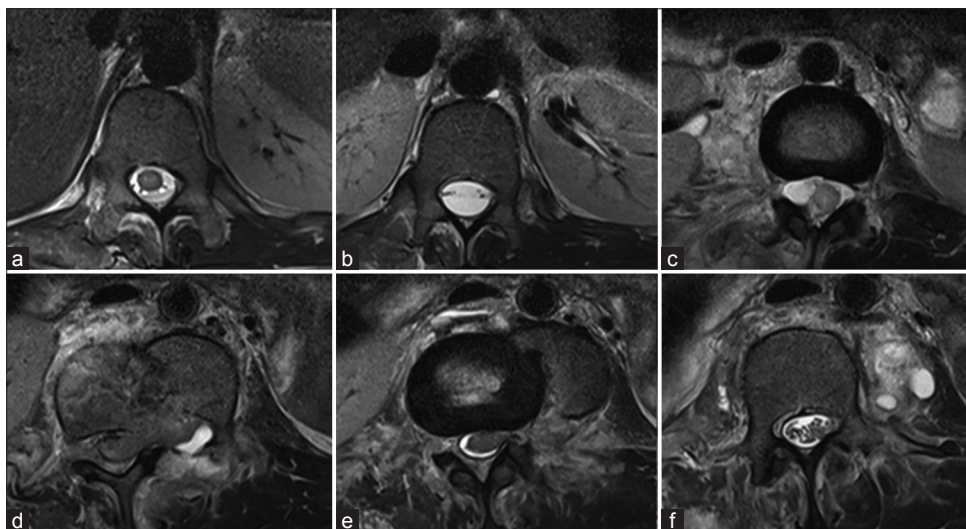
Serial axial T2-weighted images of the spine in a craniocaudal direction from the normal proximal cord to distal cauda equina. It is showing normal proximal dorsal cord (a) which is then disappearing at the level of transection with empty thecal sac (b). Distally the pulled down cord reappears (c) and can be seen traversing horizontally at L2-L3 level (d). Conus medullaris is lying at L3 (e) with cauda equina (f) distal to it
